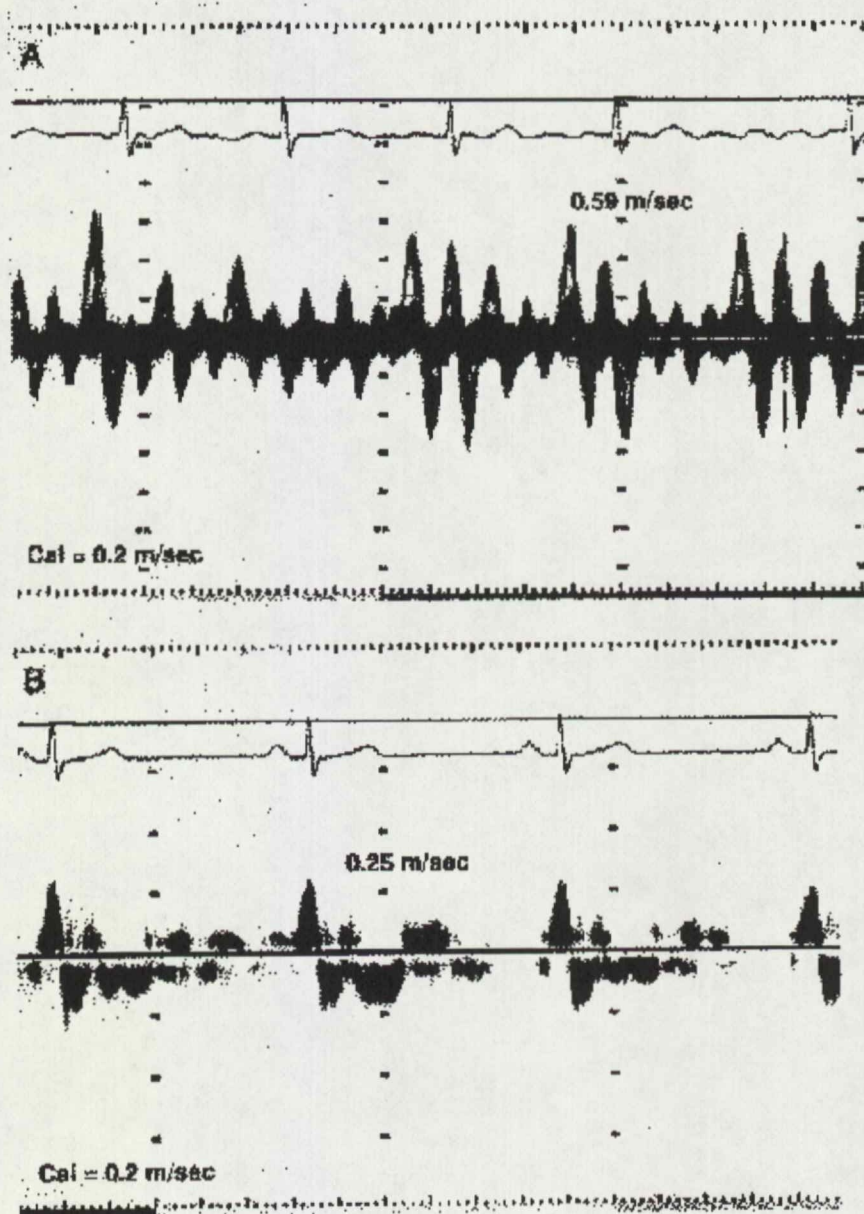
Pulsed Doppler Flow Profiles From Patient 1 in Atrial Fibrillation (A) and in Sinus Rhythm (B) Immediately After Spontaneous Conversion.
